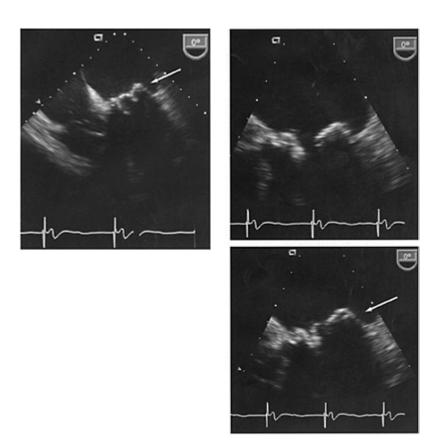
Dehiscence of a mitral bioprosthesis. Left panel: transesophageal four-chamber view in systole. An abnormal position of the bioprosthesis in systole is evident. Top right panel: open prosthesis in diastole; bottom right panel: closed prosthesis in systole. In the left and bottom right panel, the lateral circumference of the prosthesis is detached from the surrounding tissue (arrow). A comparison between the two right panels shows that the prosthesis is moving abnormally as a whole ('rocking'). There was severe paraprosthetic regurgitation.
